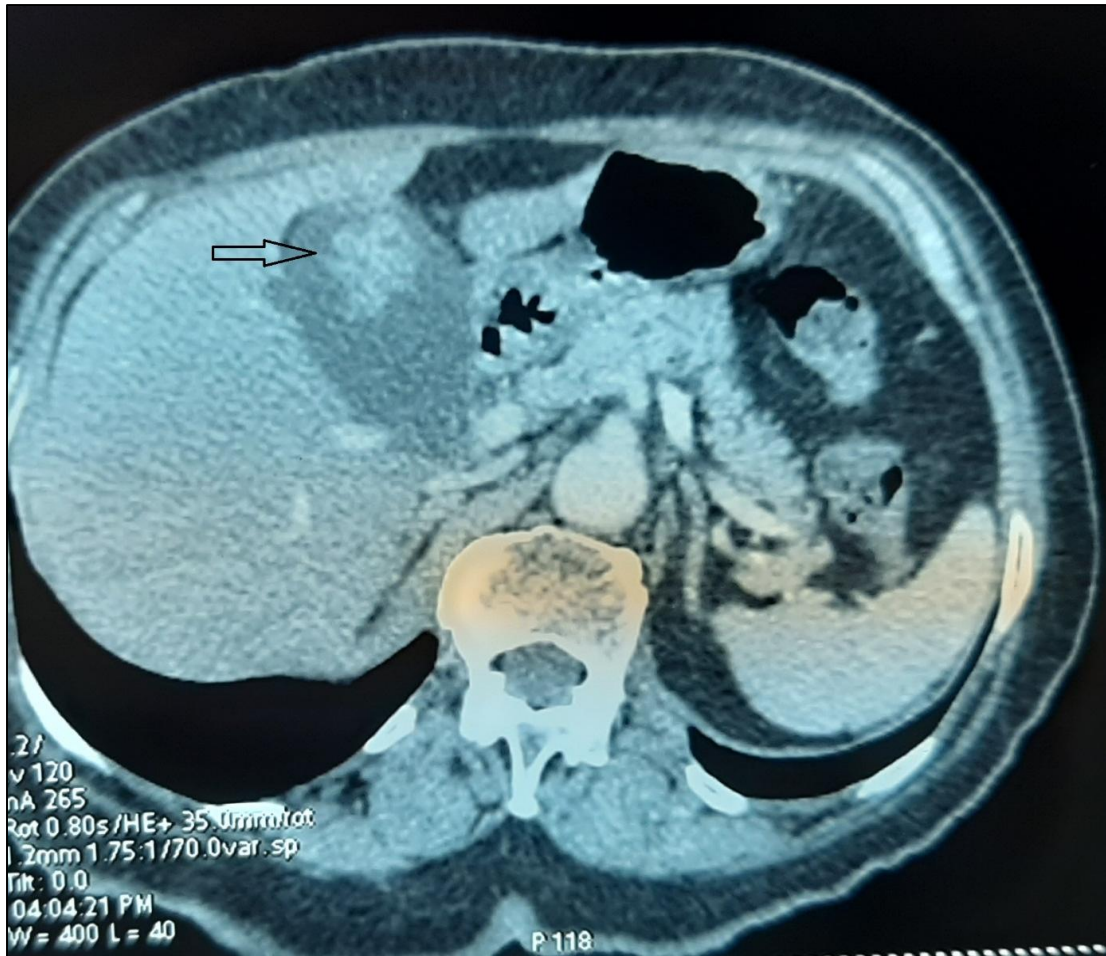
Abdominal computed tomography in axial section showing at the fundus of the gallbladder an endoluminal formation
